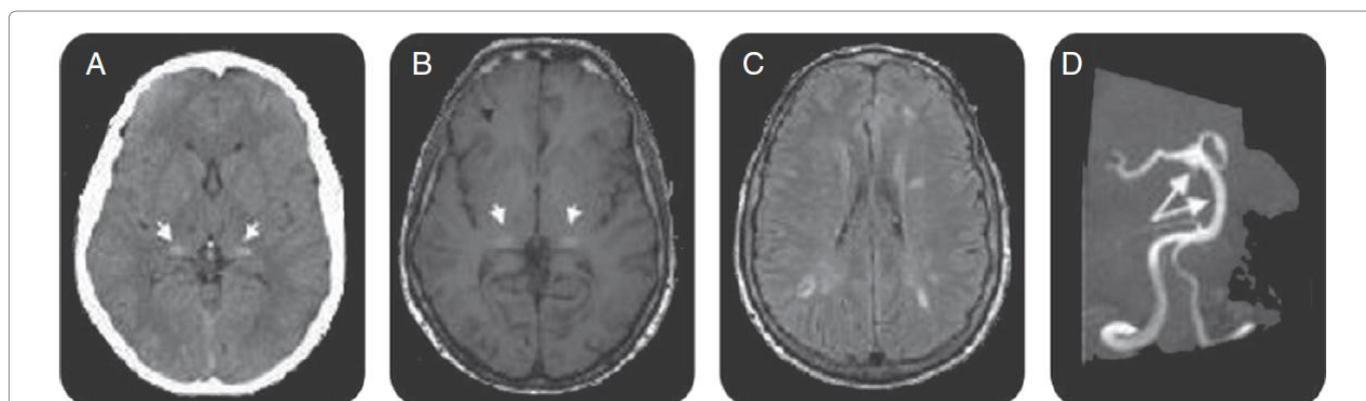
Brain CT, brain MRI, and magnetic resonance angiography for FD patients.
